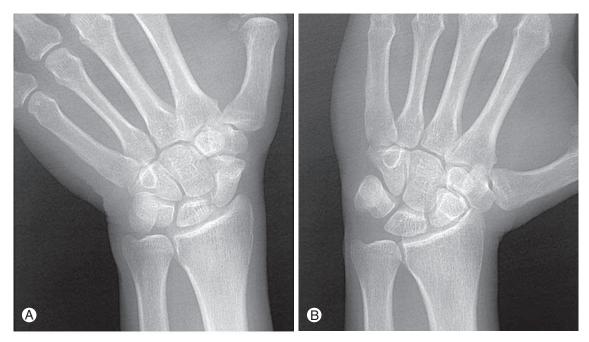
Scaphoid X-ray. Image A shows the wrist in ulnar deviation, with the scaphoid palpable in the anatomical snuffbox. B shows the wrist in radial deviation: here the radial styloid meets the trapezium in the snuffbox, and the scaphoid is not palpable. (A and B reproduced with permission from Standring 2008.)
